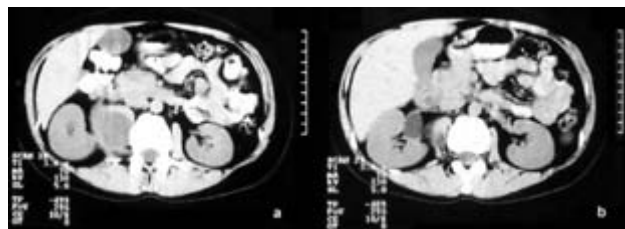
Unenhanced axial CT - scans (a, b) demonstrating a round, well-de-lineated retroperitoneal mass shifting the right kidney cranially and lat-erally.
